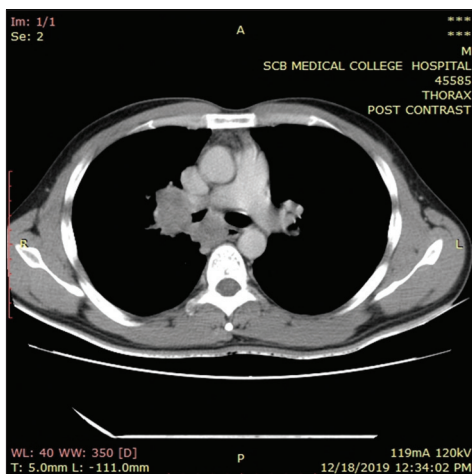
Axial section of Non contrast computed Tomography scan of thorax of a 44 year non-diabetic male patient presented with cough, fever, and sputum production in mediastinal window showing hilar lymphadenopathy
